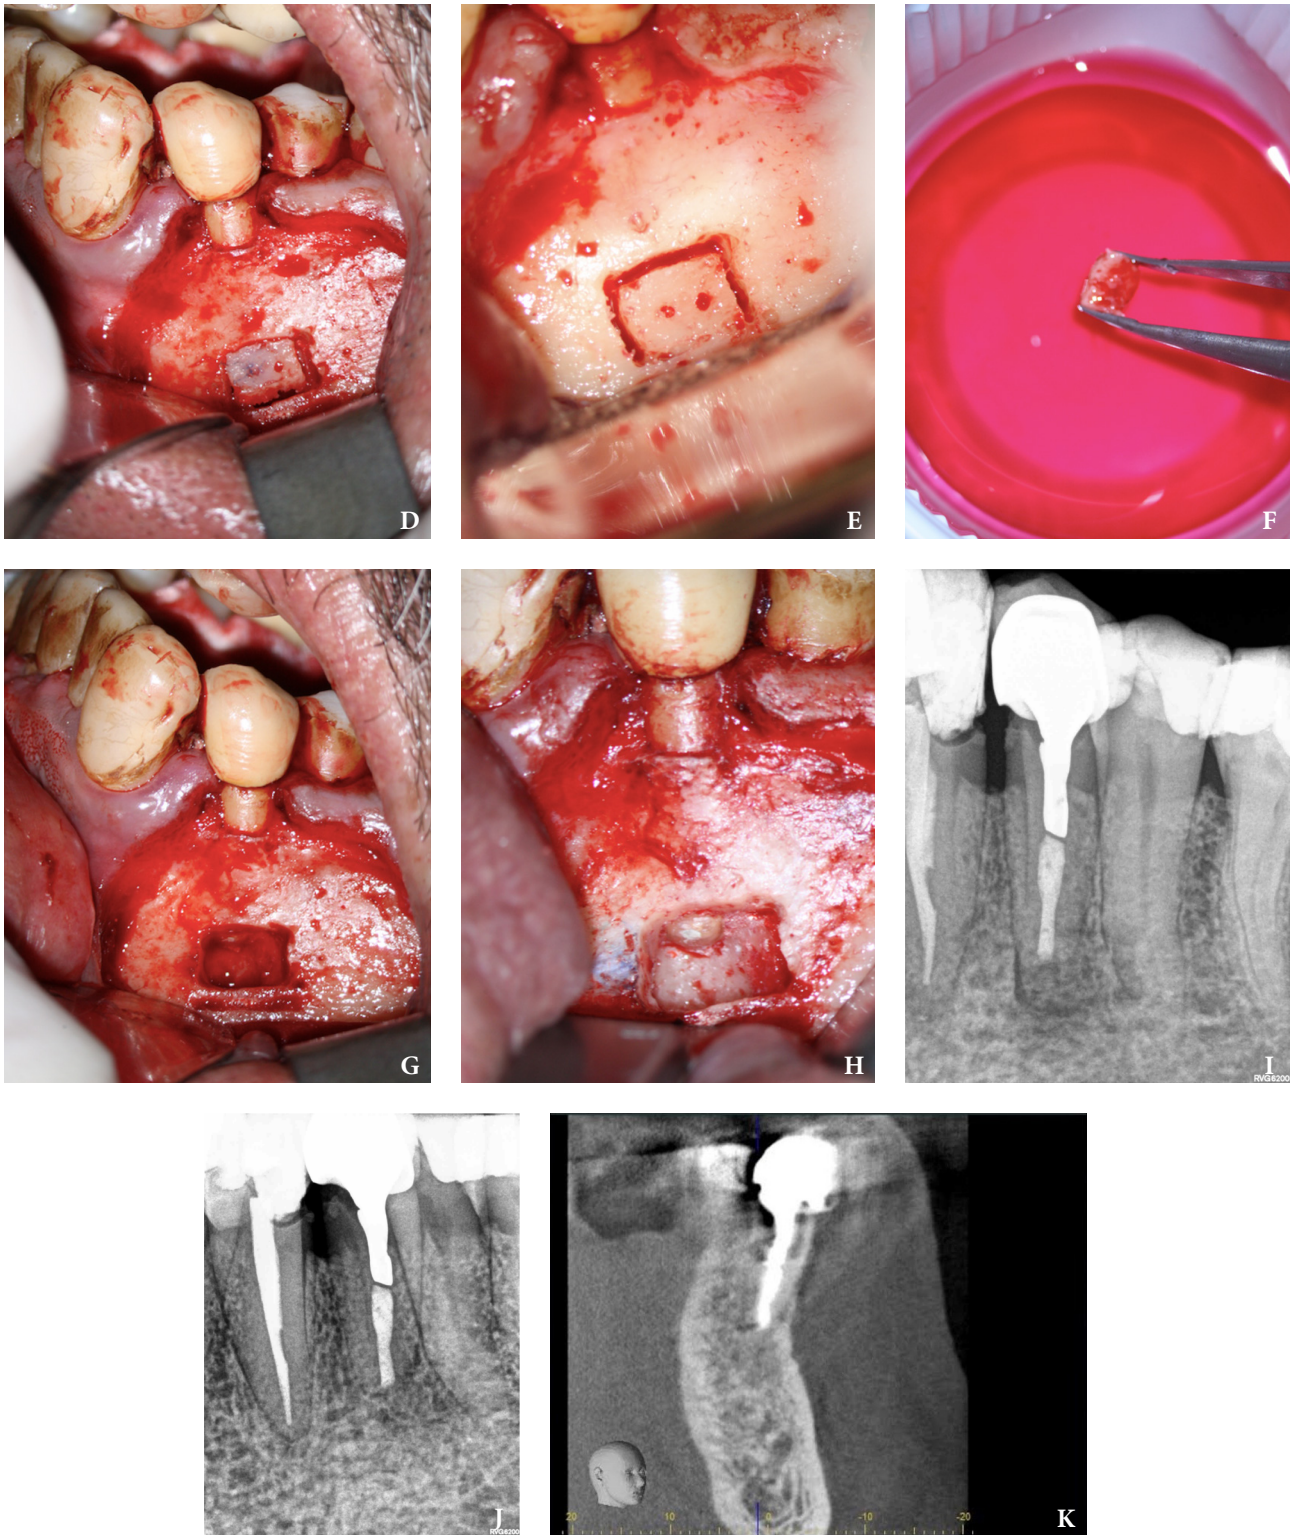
(continued). Bone window is prepared. Two openings were created to facilitate blood circulation (D, E). Buccal bone placed in HBSS hypertonic solution (F). Osteotomy site after root tip resection (G) and root end filling (H). Immediate postoperative PA radiograph of tooth #34 (I) demonstrating bone fragment reposition. 10 month follow up demonstrates healing (J) and preservation of the buccal cortical plate on the coronal view of CBCT (K).
